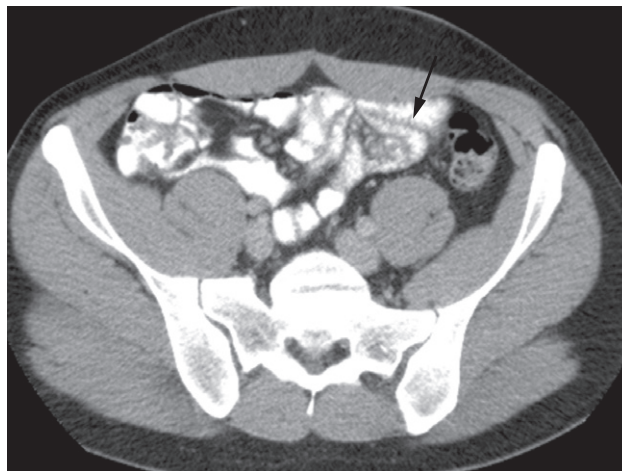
Normal CT of the small bowel. The small bowel contains Gastrografin contrast medium. Note the feathery appearance of the jejunal loops (arrow).
